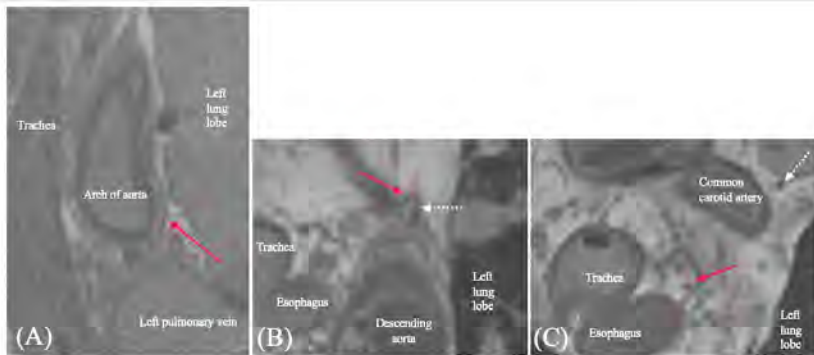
(A) Curved MPR of CISS MRI in sagittal view showing left Recurrent laryngeal Nerve (RLN) (red arrow) going around the arch of aorta; (B) Axially reformatted CISS image of left RLN as it branches off the main trunk of CN X below the arch of the aorta; (C) Axially reformatted CISS MRI of left RLN as it travels along the trachea-esophageal groove in the thorax going up to the larynx; main trunk of CN X (dotted white arrow);
